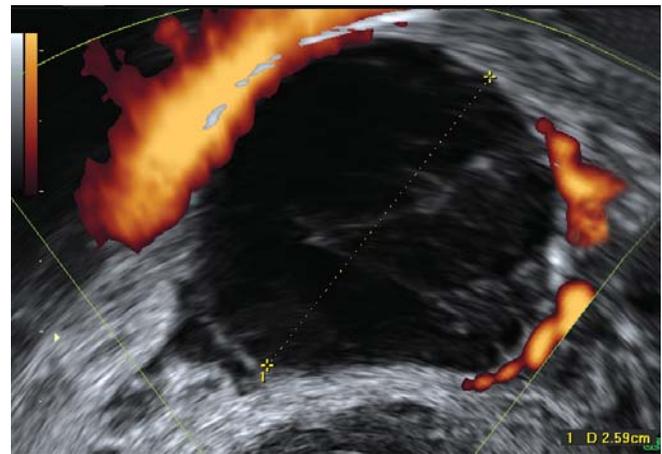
Power Doppler mode in a hemorrhagic cyst demonstrates the absence of blood vessels
